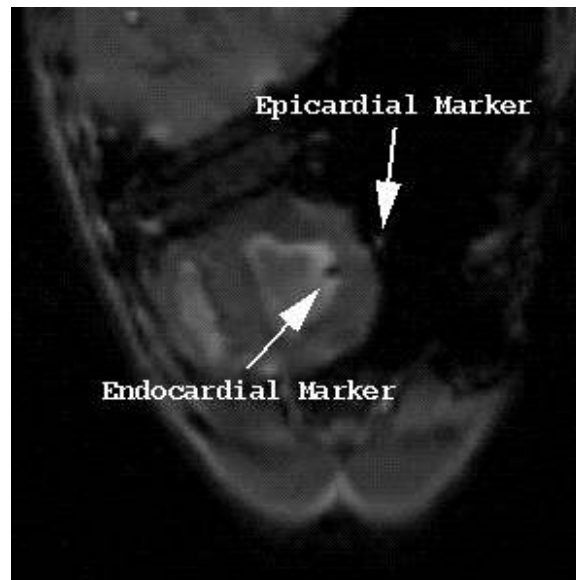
2D MR image slice of left ventricle with implanted markers. These are used to validate shape-based displacement estimates. (From Shi [90])
